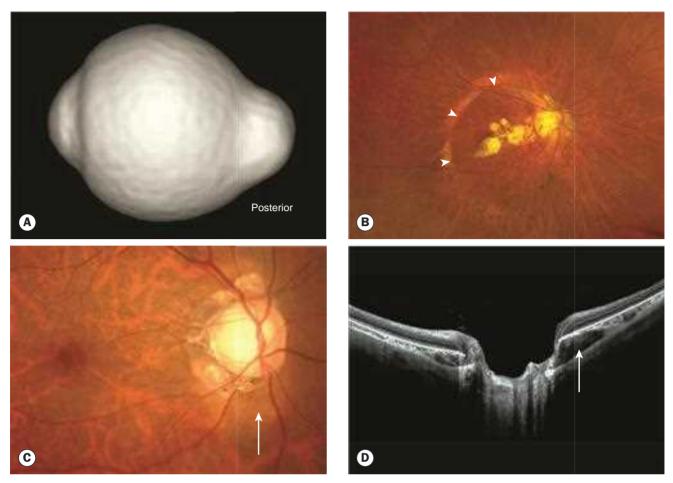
Degenerative myopia. (A) Three-dimensional MRI scan showing posterior staphyloma; (B) wide-field image of staphyloma (arrowheads mark the edge of the staphyloma); (C) intrachoroidal cavitation (ICC) (arrow marks edge of cavitation); (D) OCT appearance of ICC (arrow) (Courtesy of K Ohno-Matsui)
